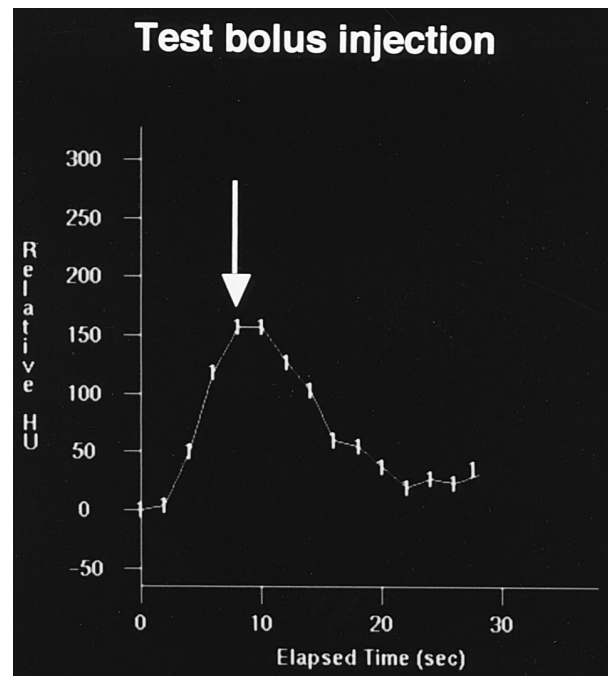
The scanning time delay is determined by using a test bolus (15 mL at 5 mL/s) of contrast medium followed by a series of single-level CT scans at a low dose (120 KVp, 10 mA). The scan location is 20 cm below the dome of the liver and the monitoring scans are acquired every 2 s from 10 to 40 s. A cursor is placed over the abdominal aorta at this level and the interval to peak aortic enhancement is used to determine the scan delay for the early arterial phase images.
